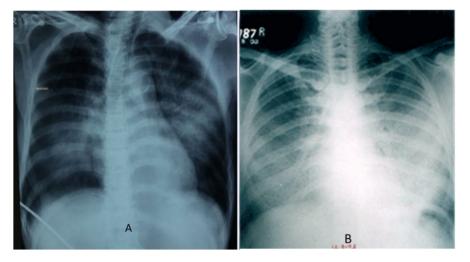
X-ray Chest showing midzone predominant interstitial opacitiesbilateral perihilar shadows in pulmonary edema (A) and Pulmonary alveolar Proteinosis (B)
